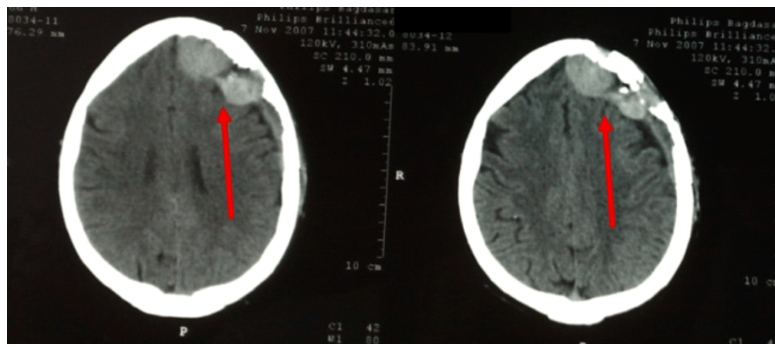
The CT scan performed before the second surgery shows the tumor remnants, the tumor again invading extracranially and no displacement of the midline structures.
